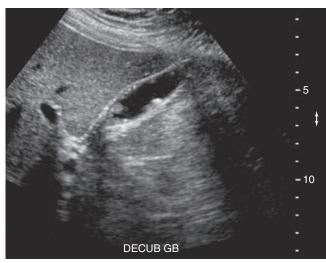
Longitudinal sonogram of the gallbladder.
